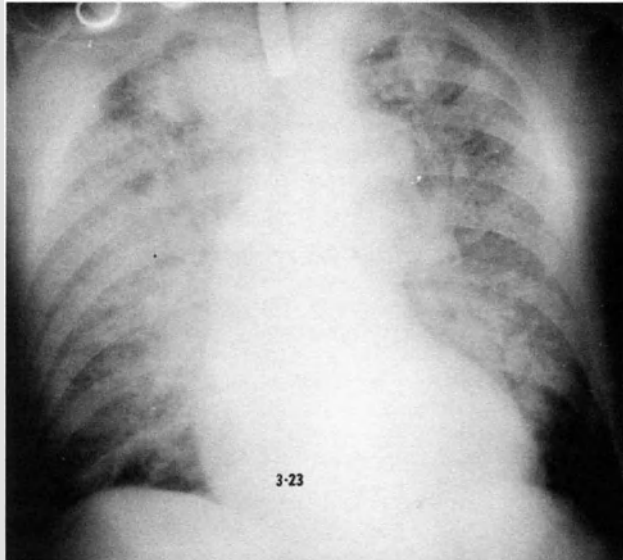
Chest X-ray in a patient with the respiratory distress syndrome. Diffuse reticular infiltrates are characteristic of the initial parenchymal changes
